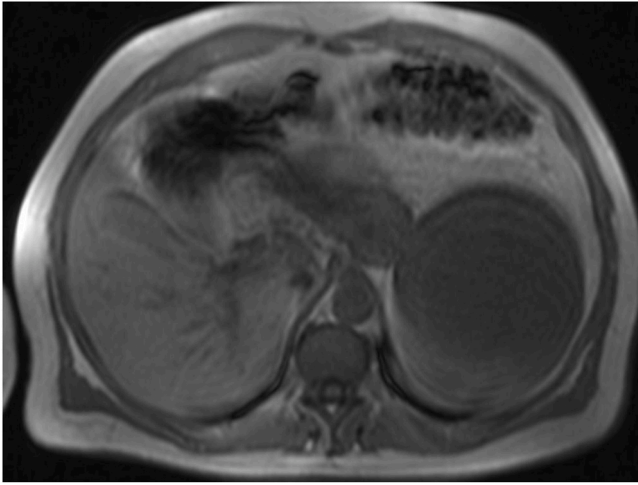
Axial MRI slice of the larger cystic lesion, described with high signal in T2 and low in T1.
